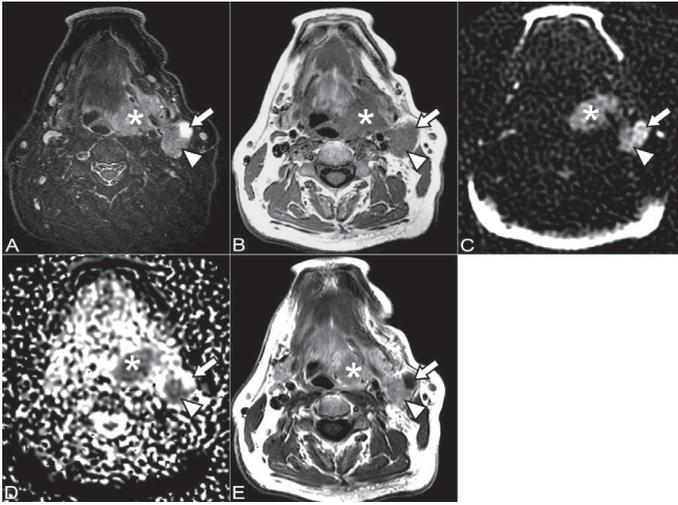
MR images in a 59-year old male patient with a T3N2c oropharyngeal carcinoma (*). Necrosis (arrow) in the level II lymph node (arrowhead) is detected on A) STIR (hyperintensity), on B) T1 minimal hypo-intensity is seen in the necrotic area. The findings of C) b750 (high signal) and D) ADC_{750} (high signal) are also indicative of necrosis. On E) CE-T1WI necrosis is seen due to low contrast-enhancement in the necrotic part of the lymph node (arrow). After 16 months of follow-up this patient remained disease free.
